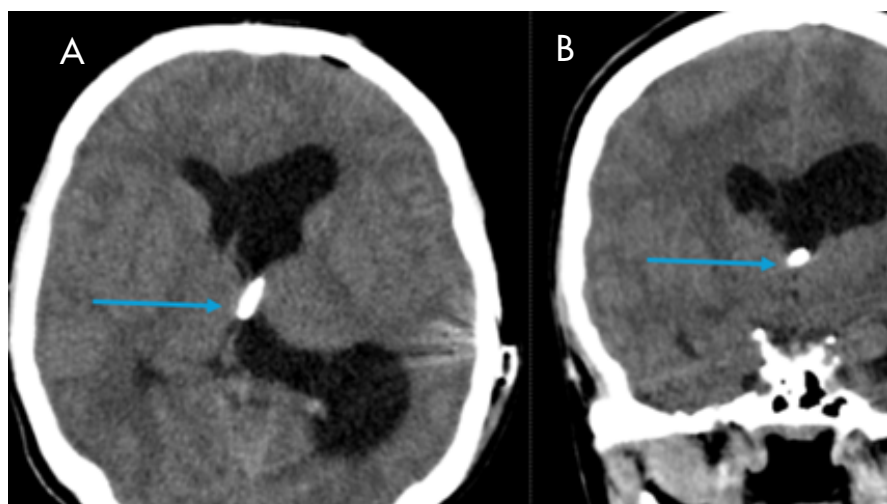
Postoperative non-contrast computed tomography of the skull (A: axial view, B: coronal view), showing a ventriculoperitoneal shunt catheter with the proximal end positioned in the interventricular foramen (foramen of Monro) (arrows).
